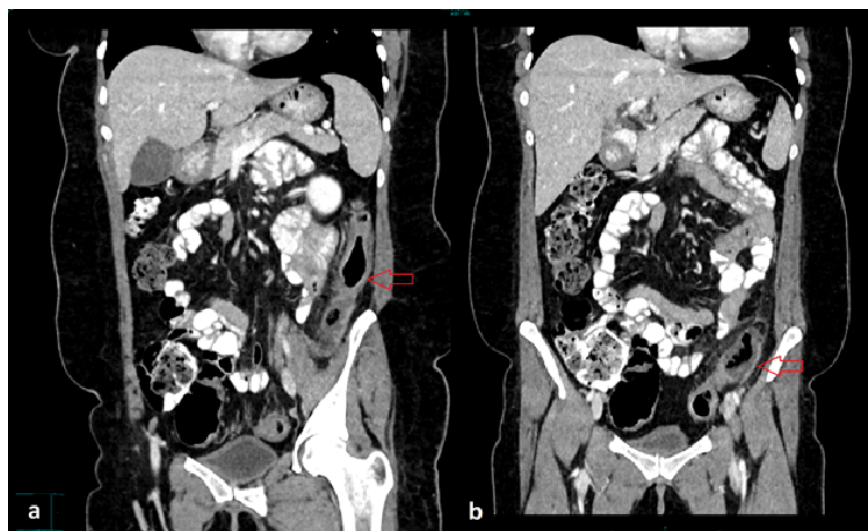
Coronal CT abdomen showing mural thickening and peri-colonic fat stranding in (a) descending colon and (b) sigmoid colon suggestive of ischemic colitis.
